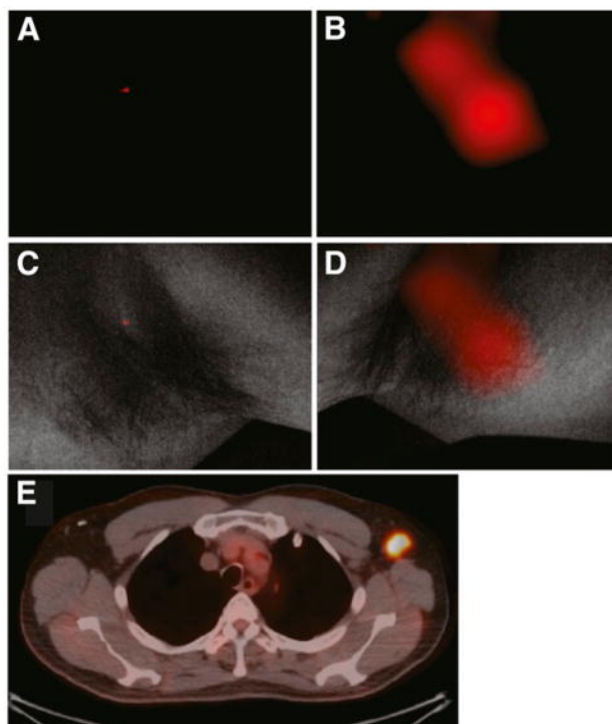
CLI and PET/CT image of a patient with a positive and negative node in the left and right axilla, respectively. CLI image and grey-scale photographic image overlaid with Cerenkov signal of negative node (A and C) and positive node (B and D). The CLI signal from the positive lymph node colocalized with the increased signal on PET/CT. *This research was originally published in (349) by the Society of Nuclear Medicine and Molecular Imaging (SNMMI), Inc.*
